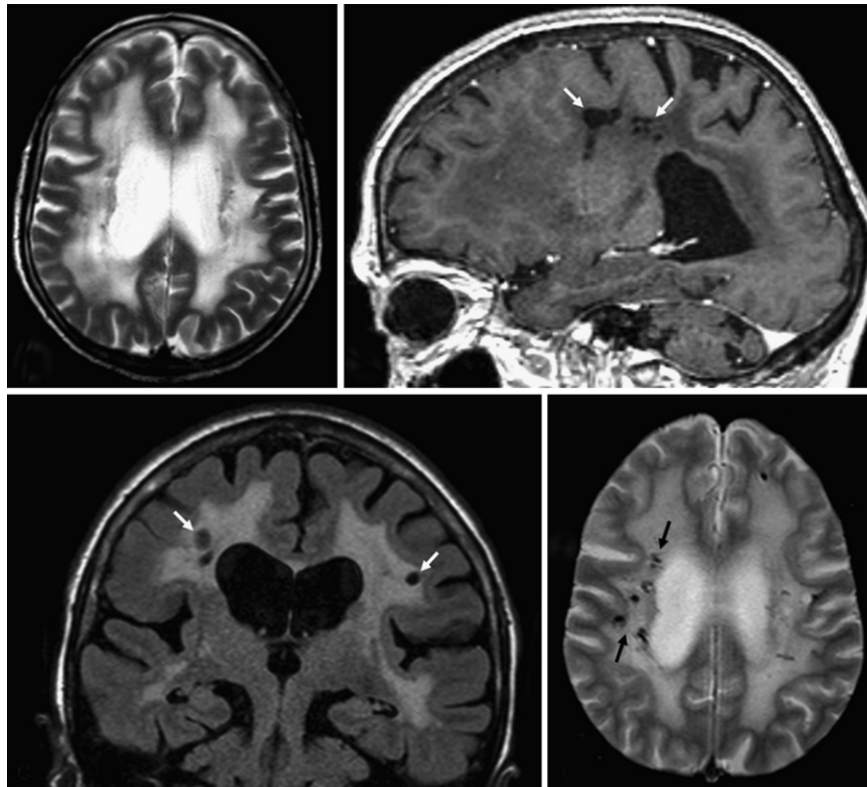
Brain magnetic resonance imaging of an individual with anterior segment dysgenesis and neurologic disease. (Top left) T2-weighted image shows extensive high signal changes in white matter. (Top right) T1-weighted image and (Bottom left) flair shows multiple fluid-filled cavities in white matter (arrows). (Bottom right) Gradient echo sequence shows hemosiderin deposits (arrows), confirming that these cavities most likely have a hemorrhagic origin.
